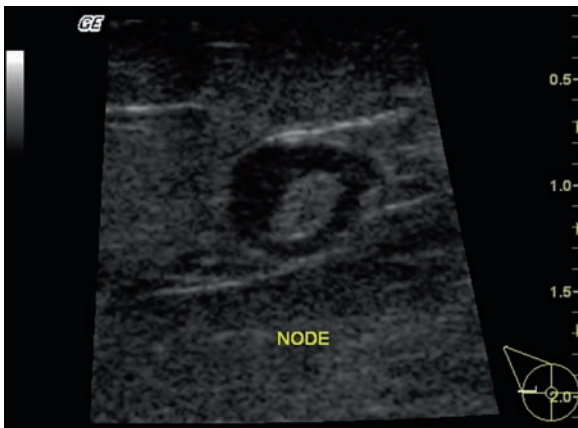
Ultrasound of a malignant axillary lymph node
